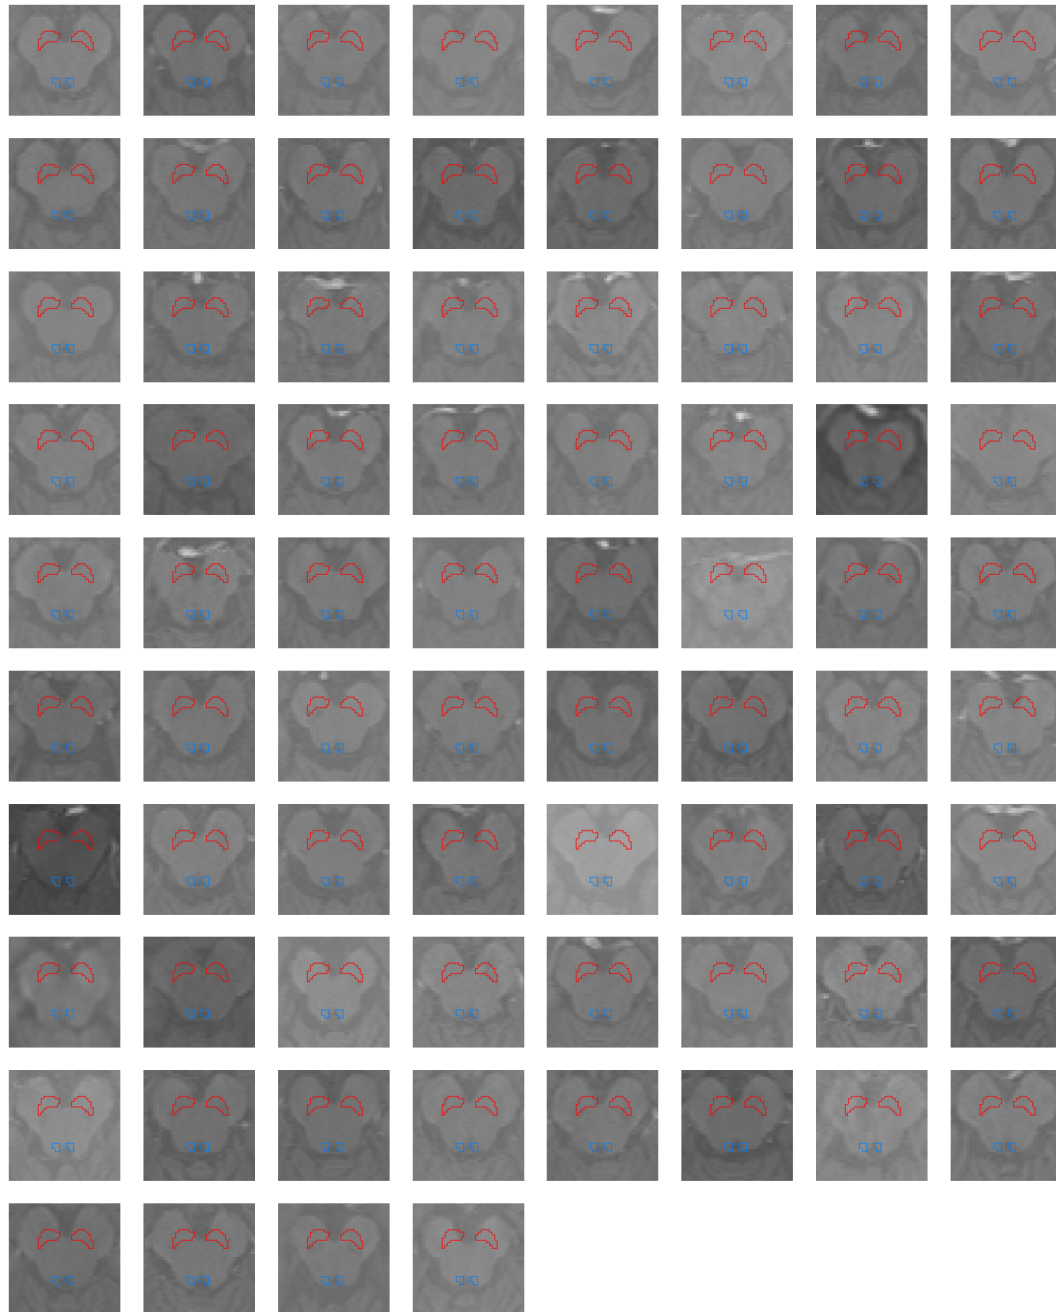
Mask outlines of the SNpc and the LC in the normalized T1WE image for all participants. The SNpc is outlined in red and the LC is outlined in blue. SNpc = substantia nigra pars compacta, LC = locus coeruleus, T1WE = T1-weighted enhanced.
